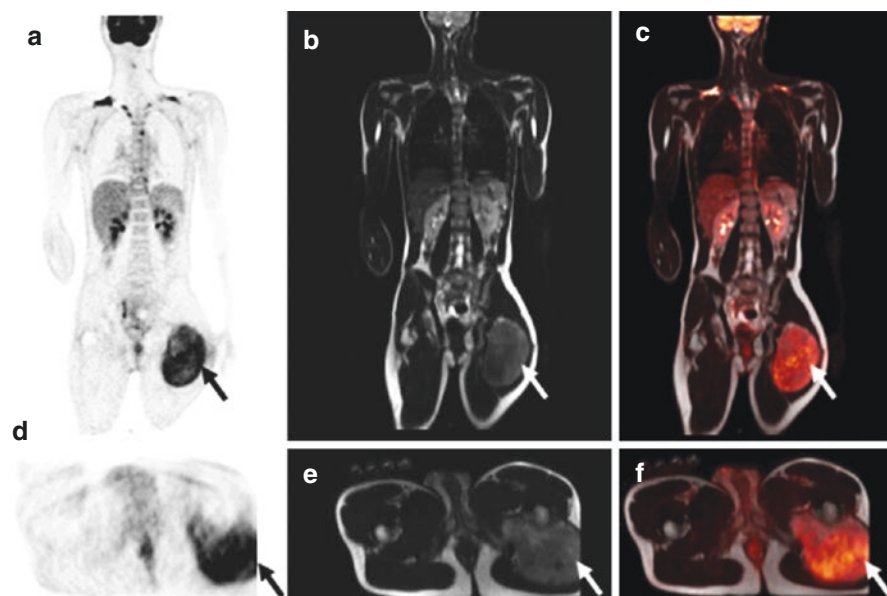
17-year-old boy with spindle cell rhabdomyosarcoma undergoing simultaneous FDG-PET/MRI for initial staging. FDG-avid soft tissue mass is seen extending into the posterior adductor compartments of the left thigh (a–c) without locoregional or distant metastasis disease. Dedicated regional PET/MRI (d–f) demonstrates avid mass with no bone marrow infiltration. (a, d) FDG-PET; (b, e) T2 single shot fast spin echo; (c, f) fused FDG-PET/MRI
